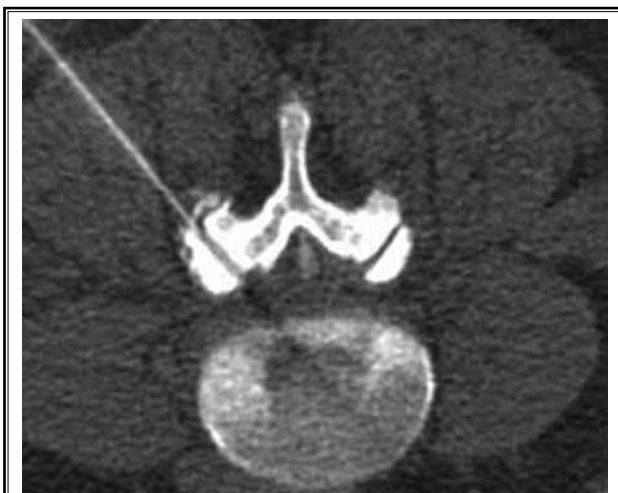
CT-guided aspiration of the right L4-5 facet joint. Note contrast is seen in the dorsal epidural cyst, confirming a connection exists with the facet joint.
